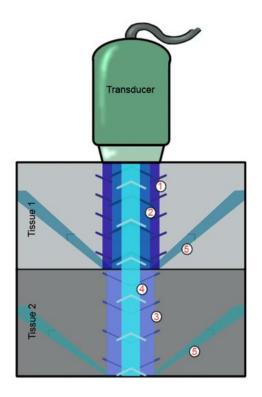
General principles of ultrasound.
